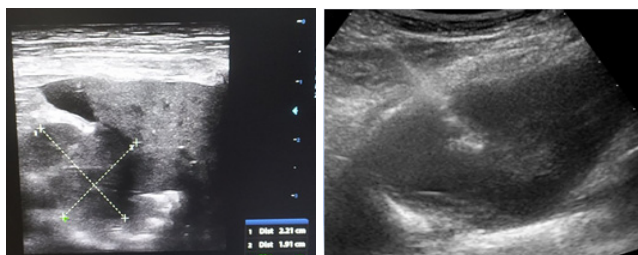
Ultrasound image in a different patient shows a central lung mass with adjacent collapsed lung and minimal pleural effusion (2A). Image 2B shows Needle biopsy of the peripheral lung mass in Ultrasound.
